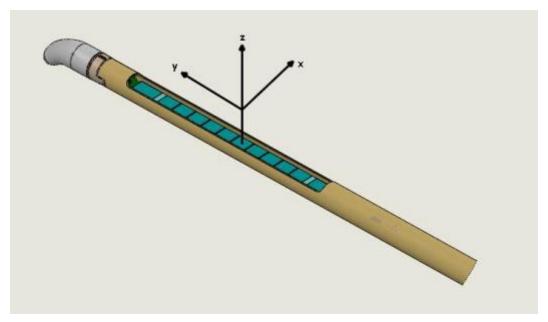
Axes of ultrasound transducer profile
